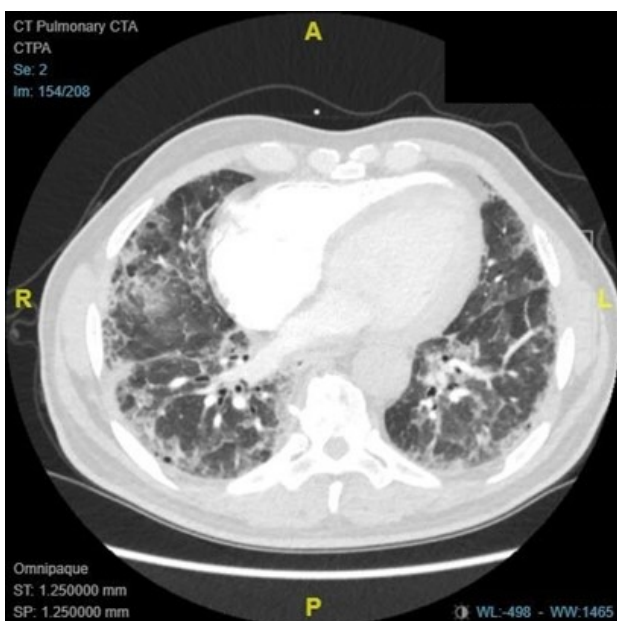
CT Pulmonary Angiography after clinical deterioration
